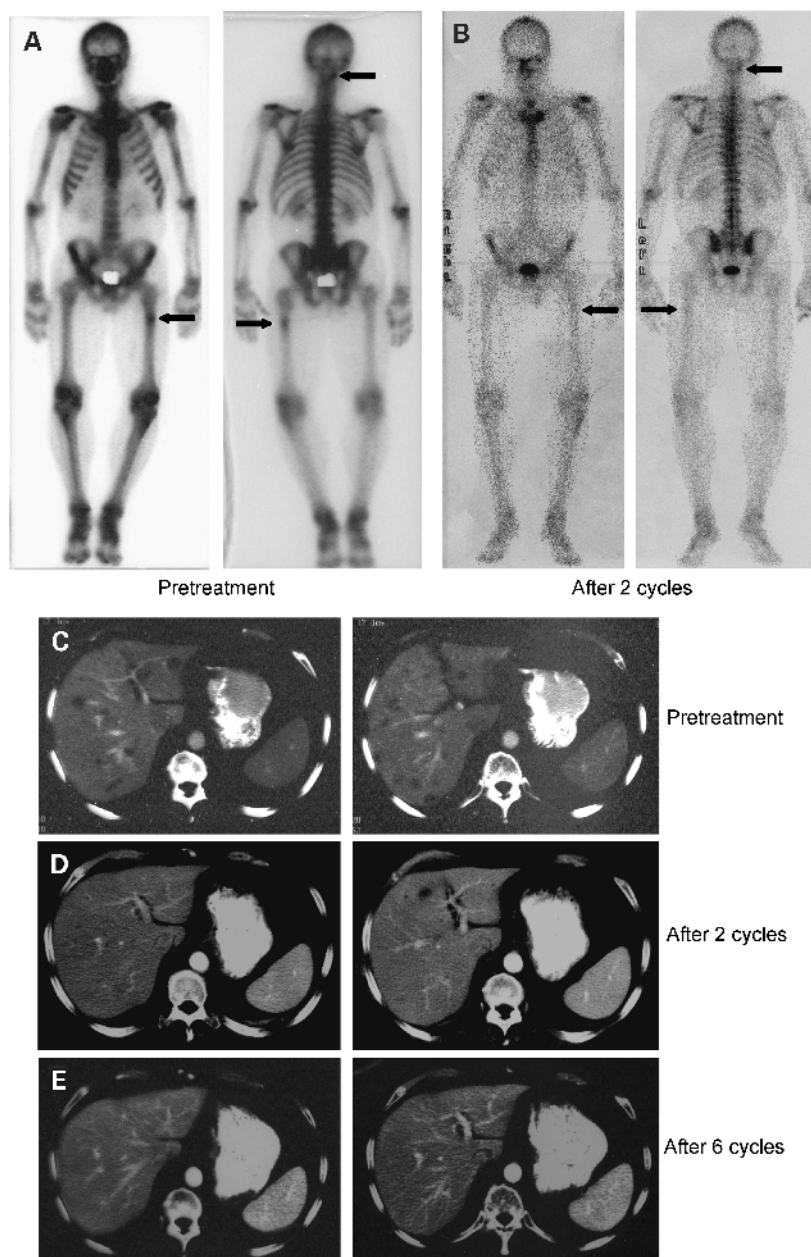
A, radionucleide bone scan and computed tomography images for a patient with metastatic melanoma demonstrating bone metastases in the femur and cervical spine at baseline (arrows). B, improvement in the bone metastases after two cycles of tasidotin; the bone scan was normalized after 12 cycles of treatment (not shown). C, liver metastases at baseline. D, dramatic improvement in liver metastases after two cycles of tasidotin. E, complete resolution of liver metastases after six cycles of tasidotin.
